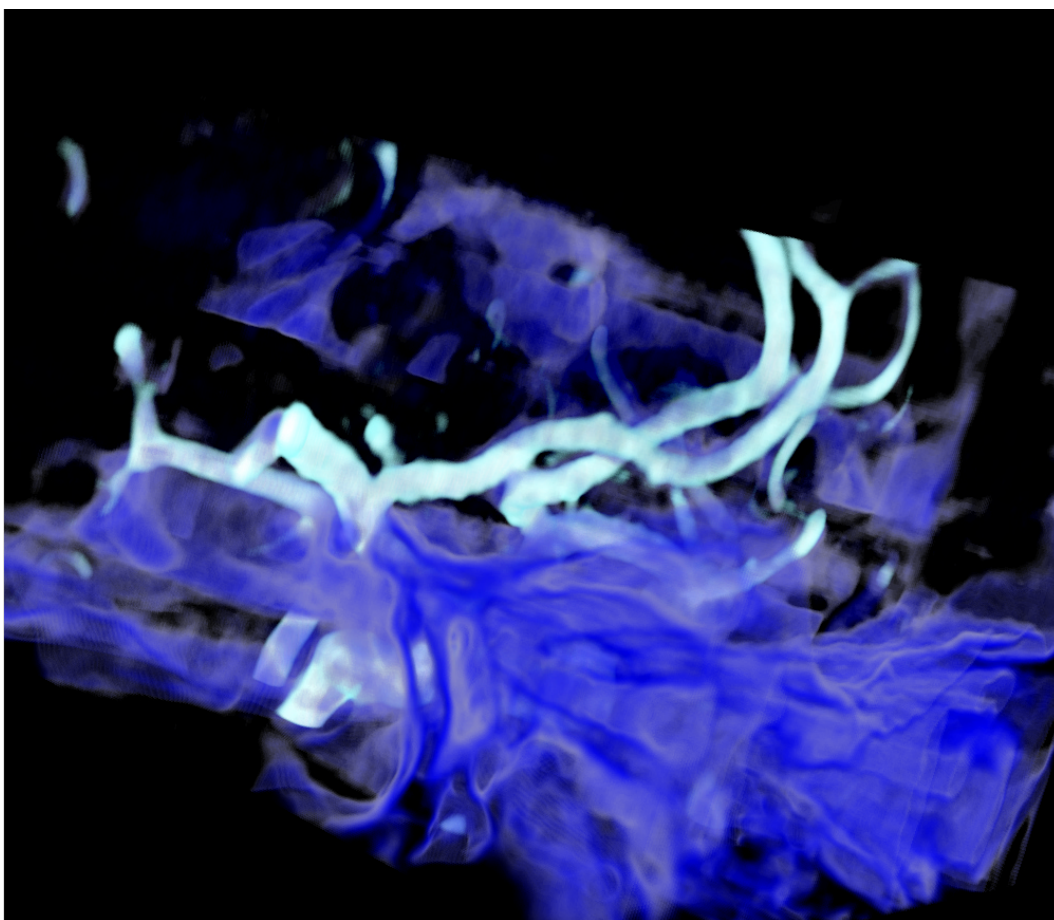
Results Aneurism 1. Volume renderings of MRI T1 (*blue*) and MRA (*cyan*) after registration.
